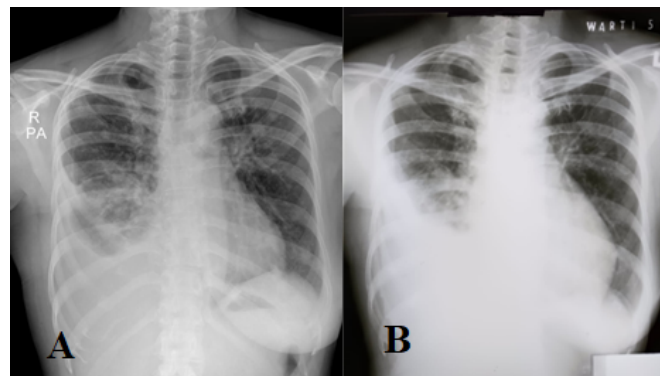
Chest X-Ray before (A) dan after 6 months of therapy (B)
